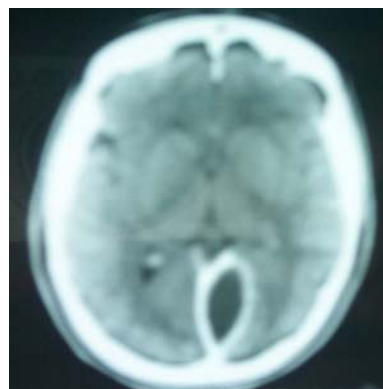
Contrast enhanced CT scan axial section showing interhemispheric subdural empyema in posterior one third region.
